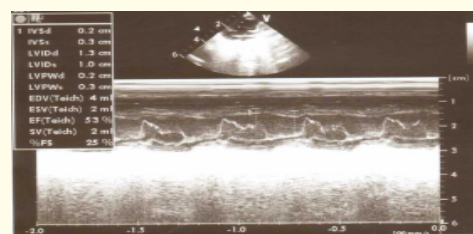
Transthoracic Echocardiography Image of Left Ventricular with Corresponding Dataset.
